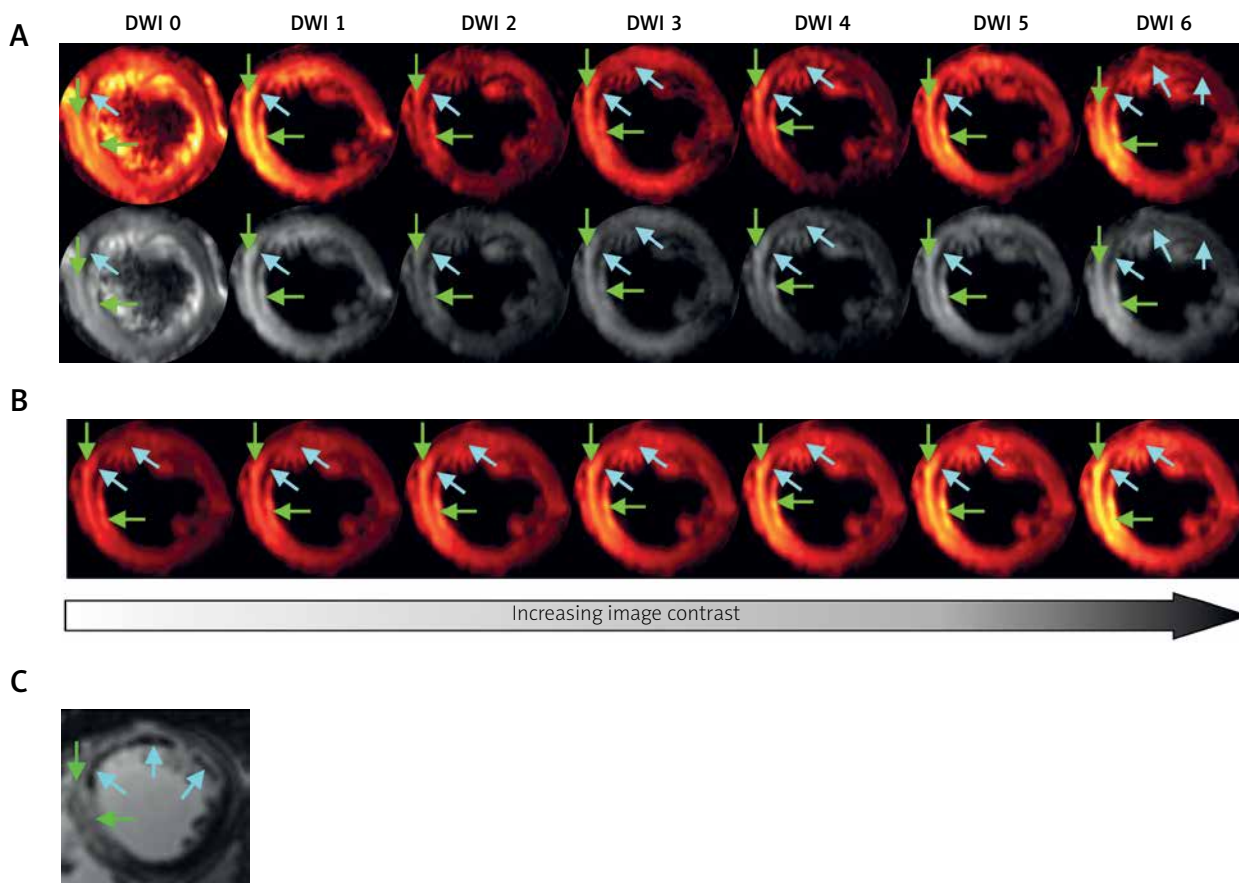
Images from patient with AMI (5 days after pPCI) obtained by using SE-EPI DTI sequence with details given previously [29]. A, B – T_i -weighted imaging with late gadolinium enhancement. A – Raw DWI images for $b = 0 \text{ s mm}^{-2}$ (DWI 0) and for six non-collinear diffusion gradient directions (DWI 1-6) required for diffusion tensor calculation: hot scale (upper row) and grey scale (bottom row); B – method for visualization of damage zones with different severity by using increasing image contrast; C – T_i -weighted image with late gadolinium enhancement. Green arrows indicate infarction area – hyperintense spots in comparison to remote tissues, while blue arrows indicate microvascular obstruction – signal loss
